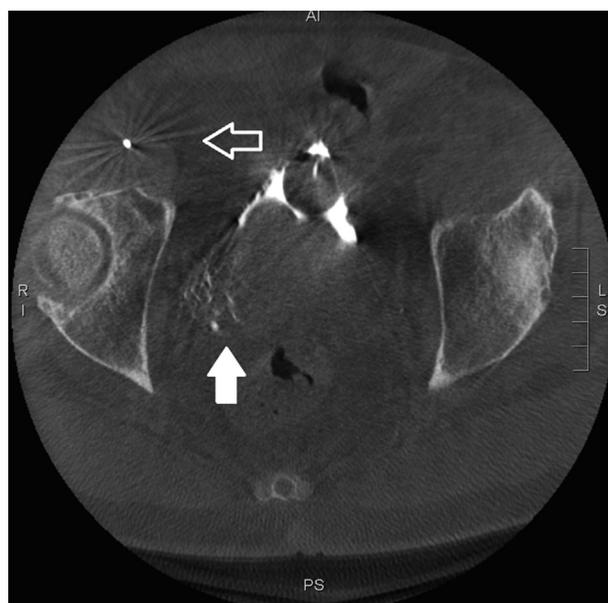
Single axial slice of a cone-beam CT angiogram with a microcatheter positioned in the right prostatic artery showing nontarget enhancement in the right seminal vesicles during an acquisition made with the low-dose, 5-second protocol. There is an increased beam hardening artifact (hollow arrow) and noise in the image, but enhancement in the seminal vesicles can be identified (solid arrow).
